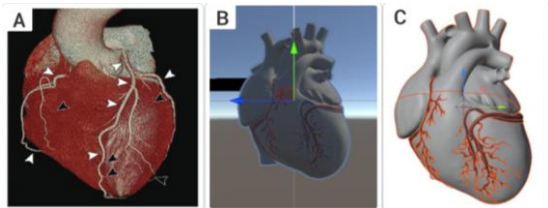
Heart Modeling Process in HDT: (A) Image from the Heart CT Scan showing blood vessels in detail. (B) Development of the 3D Heart model based on data from the CT Scan results. (C) Virtual representation of the heart in the HDT [58].
